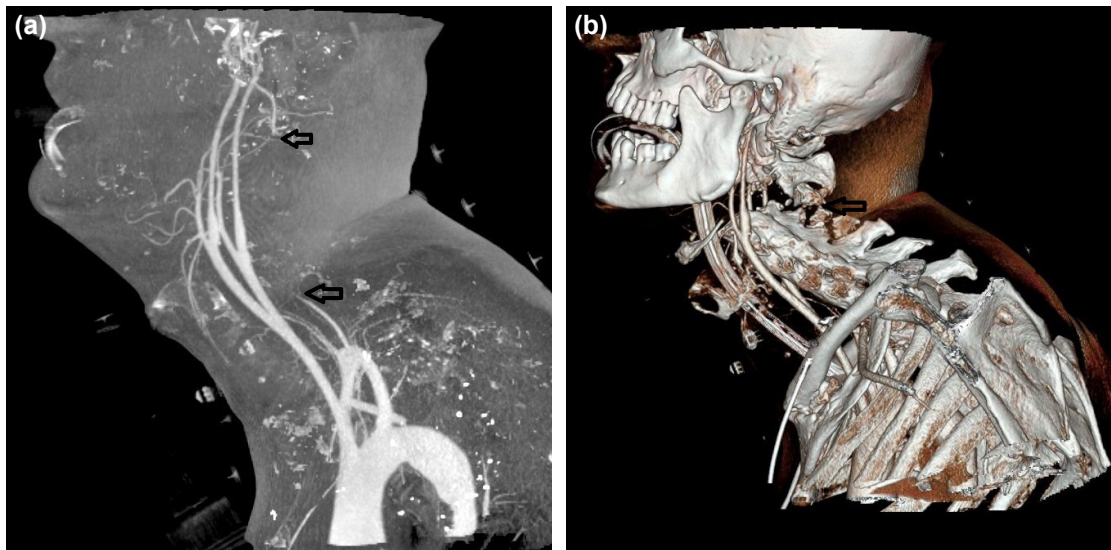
(a, b) Sagittal reconstruction of computed tomography (CT) and CT angiography revealed bilateral termination of the vertebral arteries and no blood flow was seen (black arrows).
